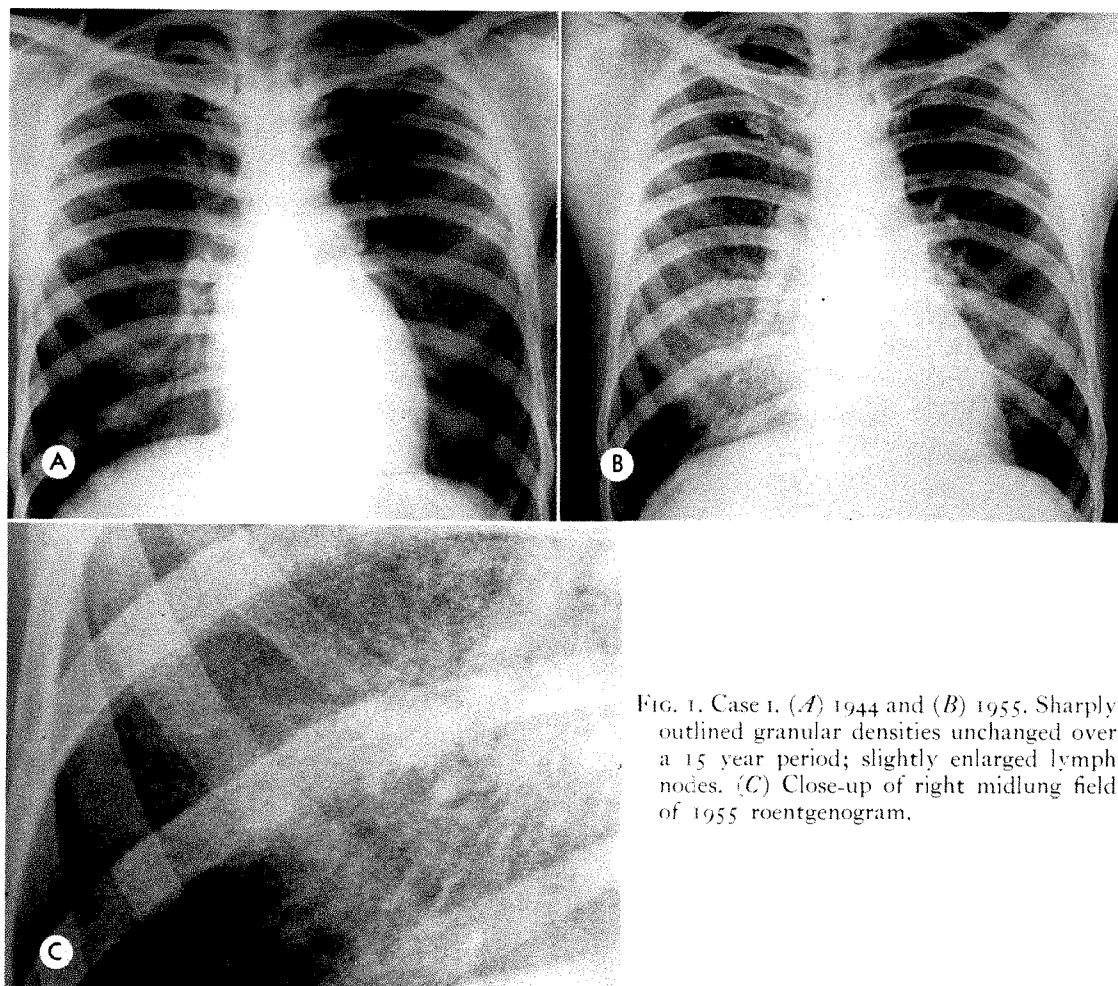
Case 1. (A) 1944 and (B) 1955. Sharply outlined granular densities unchanged over a 15 year period; slightly enlarged lymph nodes. (C) Close-up of right midlung field of 1955 roentgenogram.
